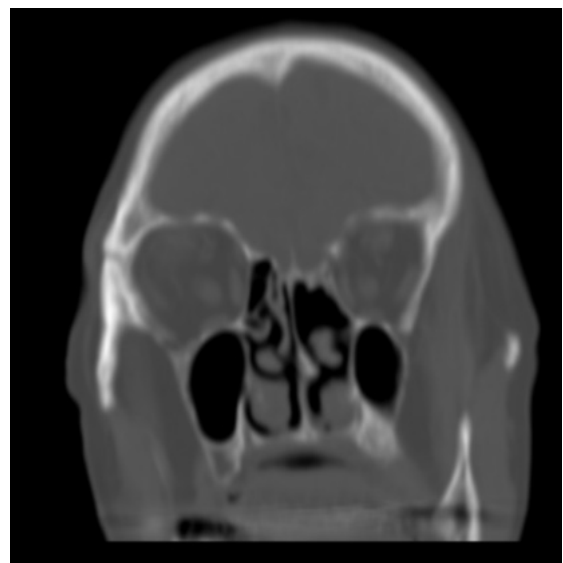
A paranasal CT of the coronal view in the sixth month after chemotherapy showing regression of the existing lesion in the previous imaging studies
